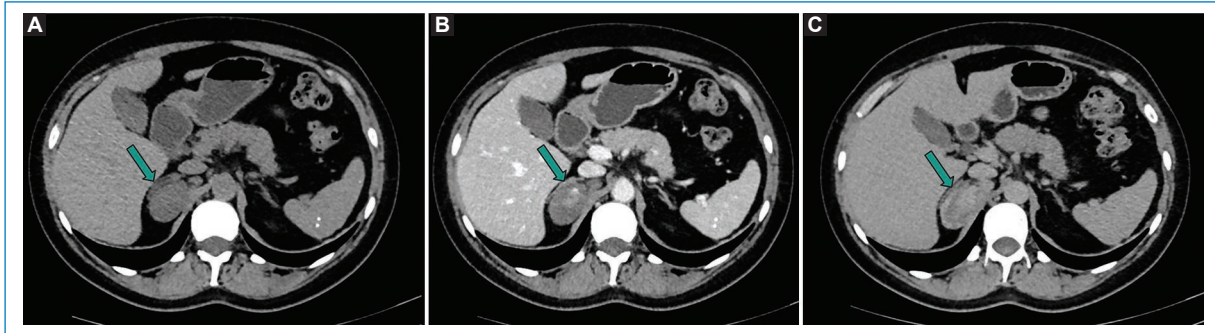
48-year-old woman. (A–C): abdominal computed tomography with intravenous contrast: well-defined nodular lesion (arrow) adjacent to the right adrenal gland with heterogeneous and progressive enhancement. Diagnosis of neurogenic tumor with ganglionic elements, without elements of malignancy.
